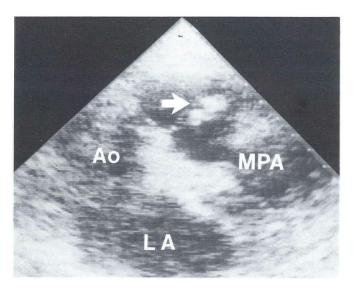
Two-dimensional echocardiogram (parasternal short axis view) demonstrating thickened pulmonary cusps (arrow) compatible with vegetations. (AO = aorta, LA = left atrium, MPA = main pulmonary artery.)
